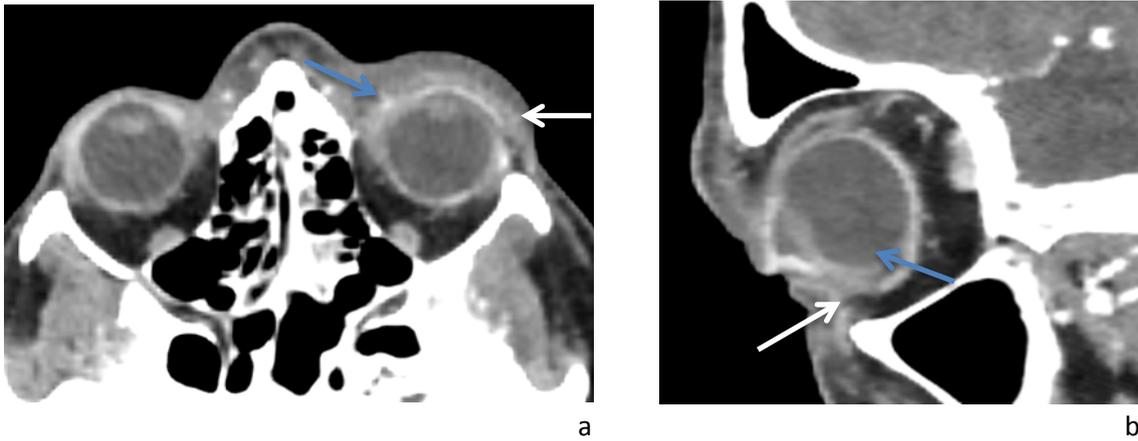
(a/b): Totally ruptured globe, left eye (37-year-old female, wearing sunglasses while accident). CT, axial section (a): Irregularities of the bulbar wall (white arrow), volume loss and dislocated lens (blue arrow). Sagittal reconstruction (b).
